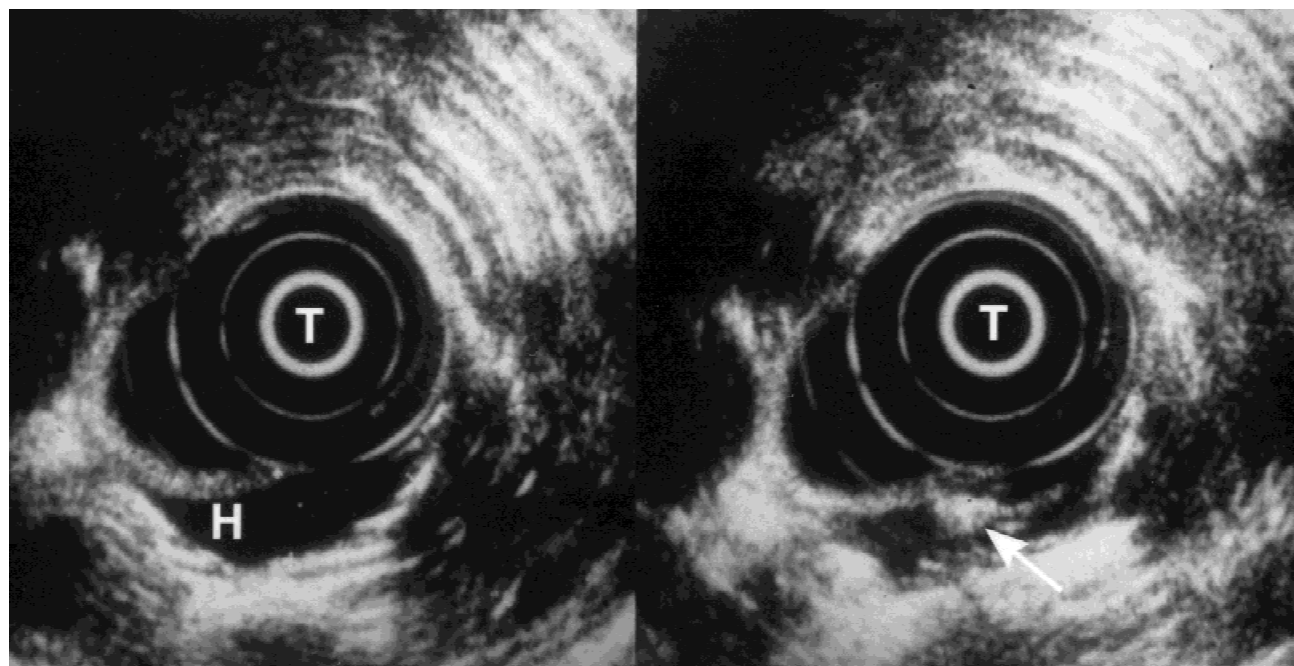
Endo-ultrasound control of laser tissue interaction in a transmurular hemangioma of the distal dorsal trachea. The 7.5 Mhz transducer (T) is placed in the esophageal lumen. On the right is the hyperechogenic coagulation effect (arrow) in the tracheal hemangioma (H) after 40 seconds of continuous interstitial laser irradiation with 4 W.
